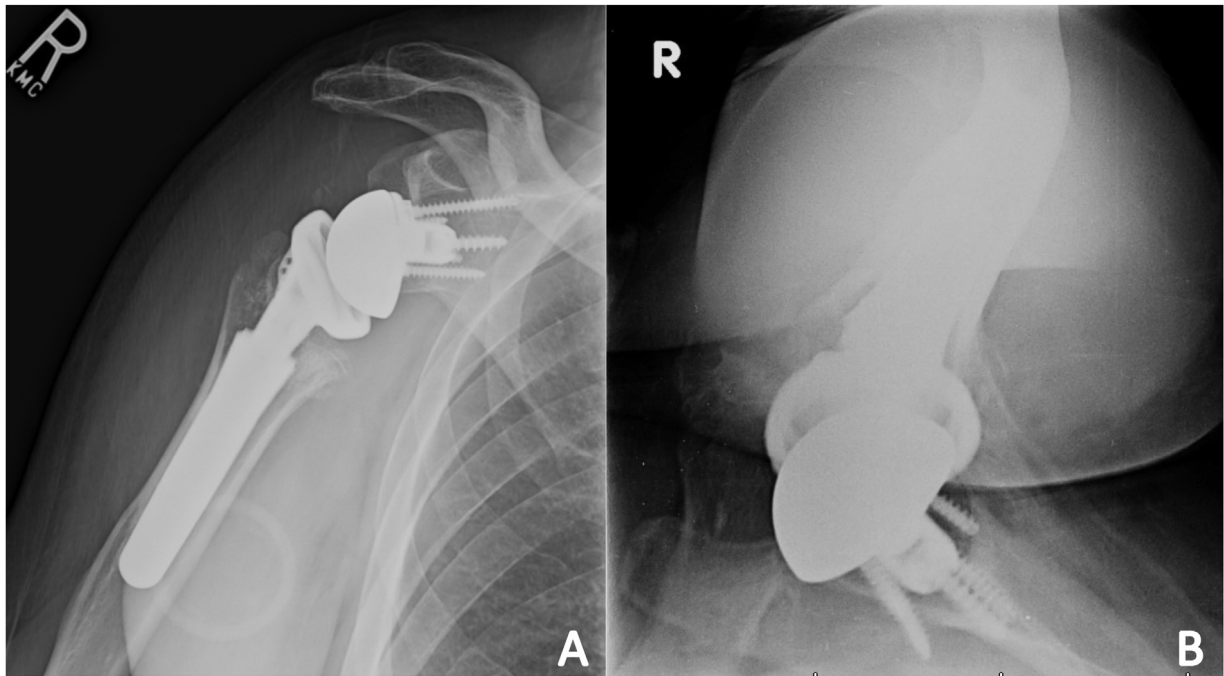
(A) Post-operative AP radiograph of the right shoulder status post reverse total shoulder arthroplasty. (B) Post-operative axillary lateral radiograph of the right shoulder status post reverse total shoulder arthroplasty.
